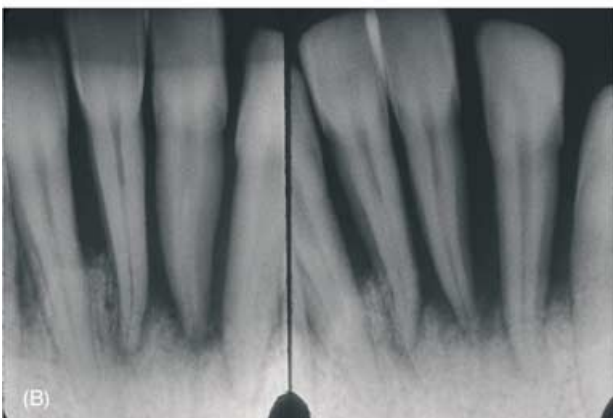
Advanced localized aggressive periodontitis in a medically healthy 19-year-old Caucasian male. Note that there are minimal amounts of plaque and gingival inflammation (A). Radiographs of the mandibular anterior teeth showing the massive amount of bone loss (B). The periodontal damage was confined to the permanent incisors and first molars.
